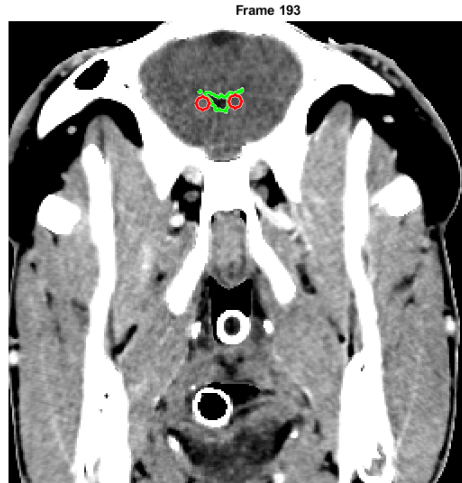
A slice of the CT scan with lateral ventricle segmented (Area with Green boundary) and the Caudate Nucleus segmented (Red Circles)
